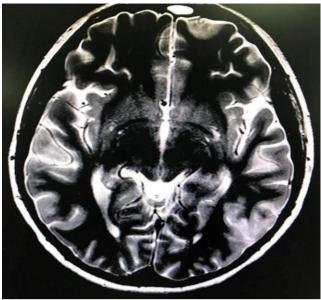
MRI: Bilateral cortical patches of altered signal intensity are seen distributed in the parka to-occipital lobes. It is hypo intense on T1-weighted image &hyper intense on T2 and FLAIR images, water restriction in DWI posterior reversible encephalopathy syndrome is the first differential.
